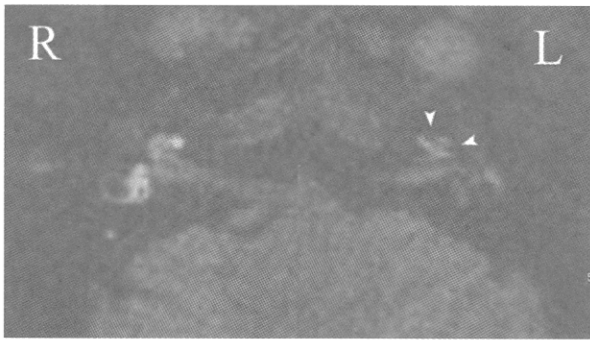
MRI imaging in patient no. 3 (definite Meniere's disease). The endolymphatic hydrops is detectable as a black area (arrowheads) inside the perilymphatic space filled with the gadodiamide in the basal turn of the left cochlea. In the normal side, the endolymphatic space (a significantly small area) is not detectable, probably due to strong signal intensity in the perilymphatic space.
